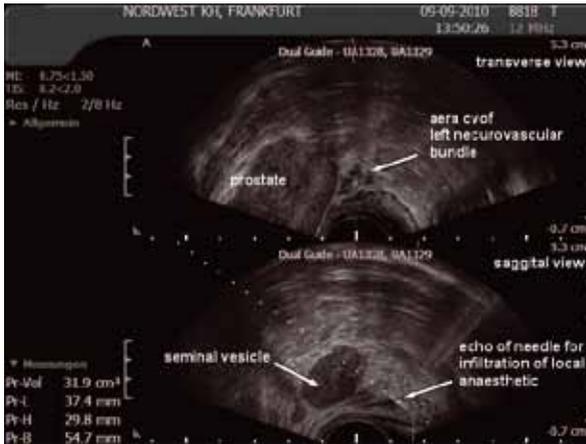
Ultrasound image of injection of local anaesthesia
